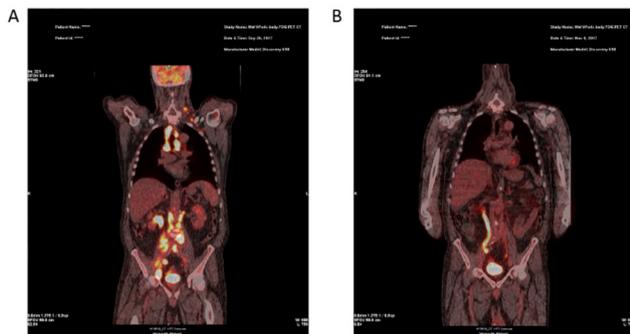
Positron emission tomography-computed tomography image of a patient with diffuse large B cell lymphoma (DLBCL) before (A) and after (B) treatment with two courses of R-CHOP chemotherapy. Areas of high intensity signal are seen in the left neck, mediastinum, and para-aortic and iliac lymph nodes. Resolution is seen in the interim treatment scan. The high intensity seen in the right ureter and bladder represents normal excretion of the tracer
